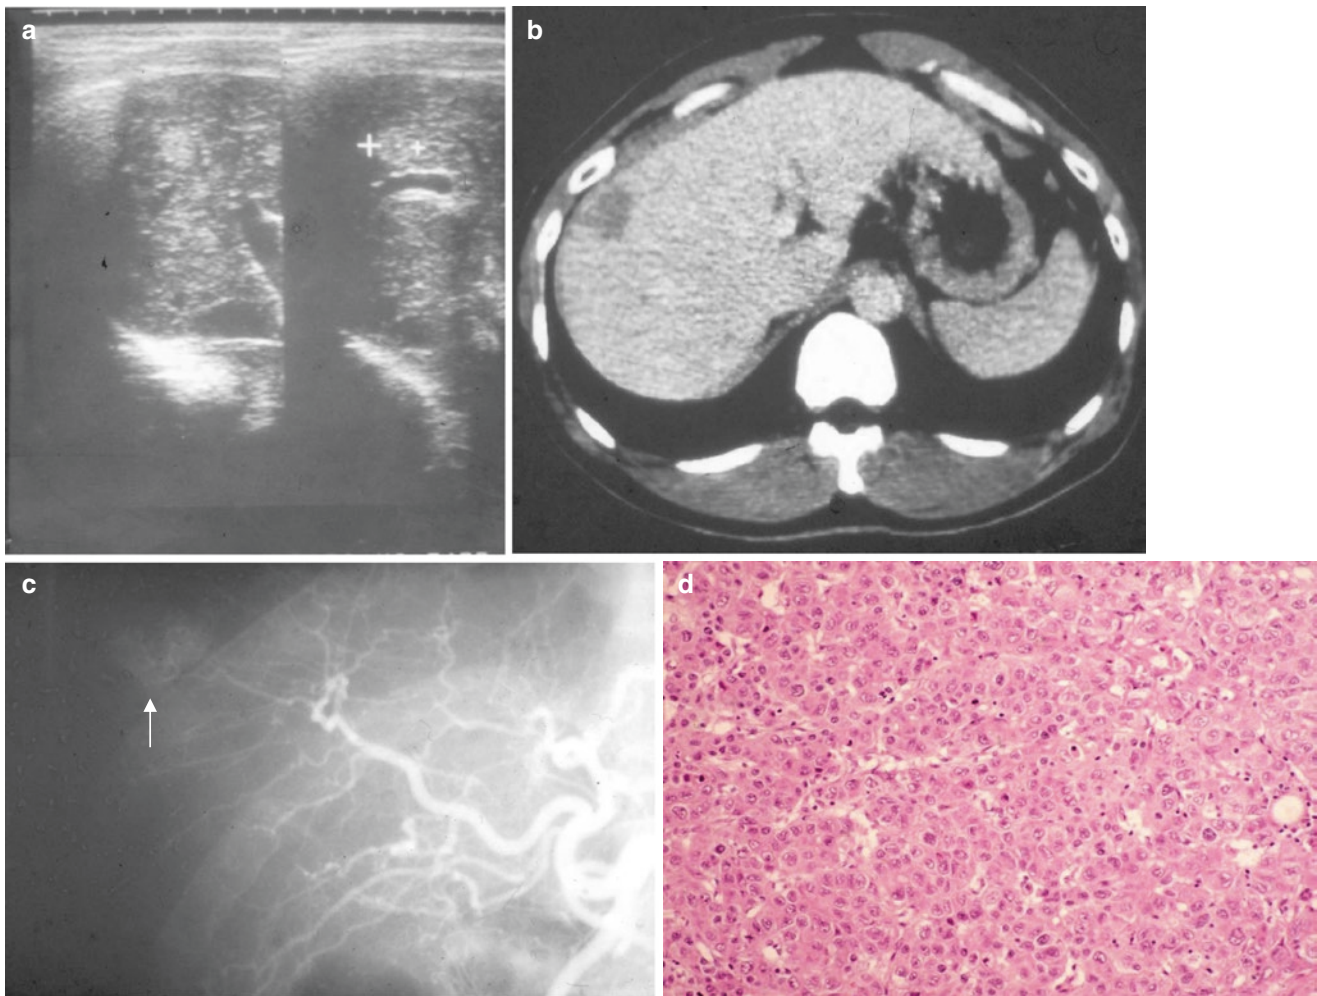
Progressed hepatocellular carcinoma. US shows hyper-echoic lesion of diameter 1.5 cm in S8 (a). CT with contrast medium shows the presence of a low-density area in the late phase (b). Common
